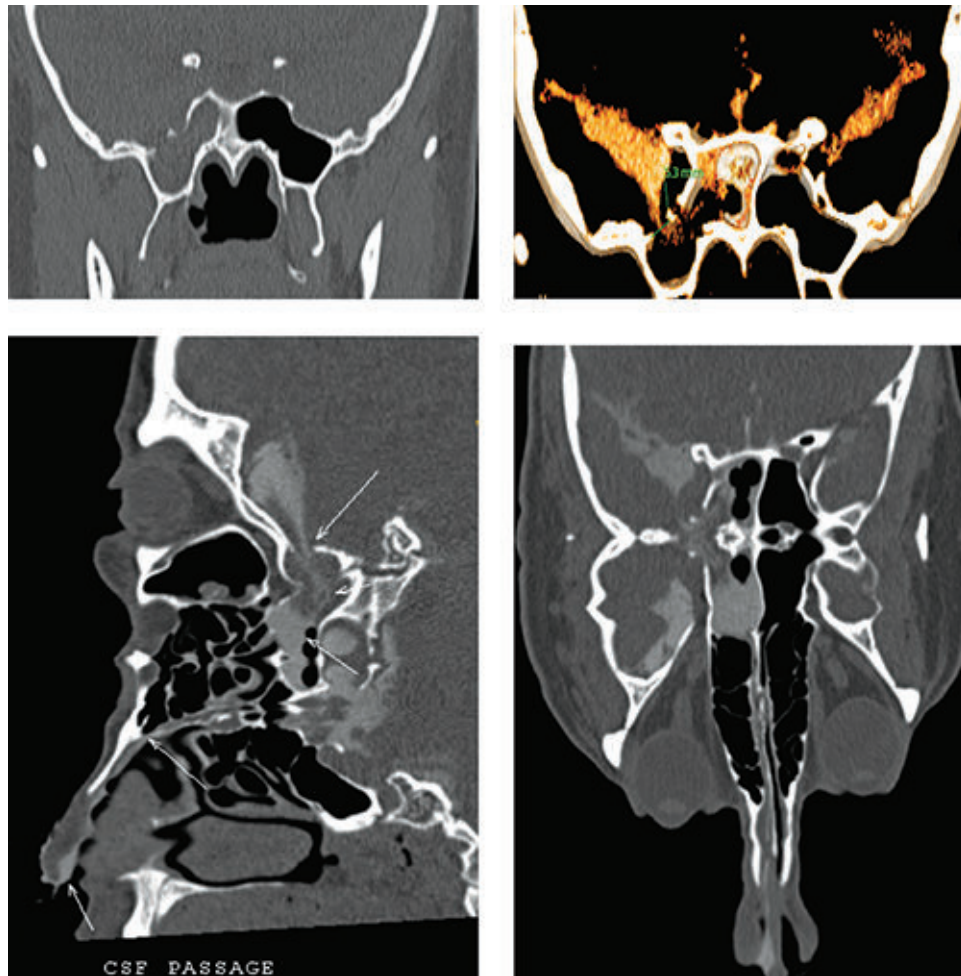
Non-contrast CT with bone window in the coronal plane (A) shows a defect in the lateral wall of the right sphenoid sinus. CT cisternography volume-rendered image (B), sagittal (C), and coronal (D) reformatted images demonstrate contrast leakage into the right sphenoid and adjacent ethmoidal sinuses.
